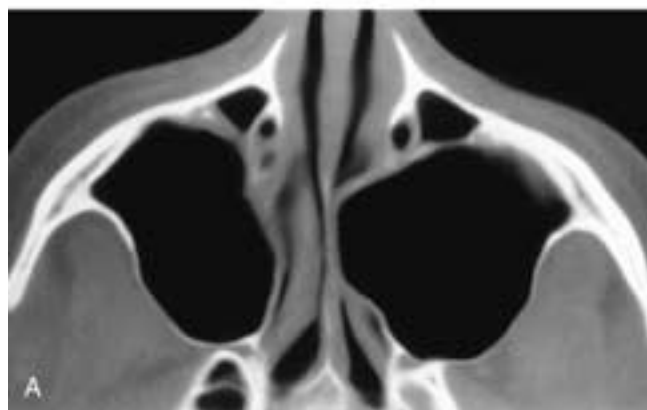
Axial (A) and coronal (B) CT scans show an aerated, expanded left maxillary sinus. The sinus walls are thinned. This patient had a pneumocele.
